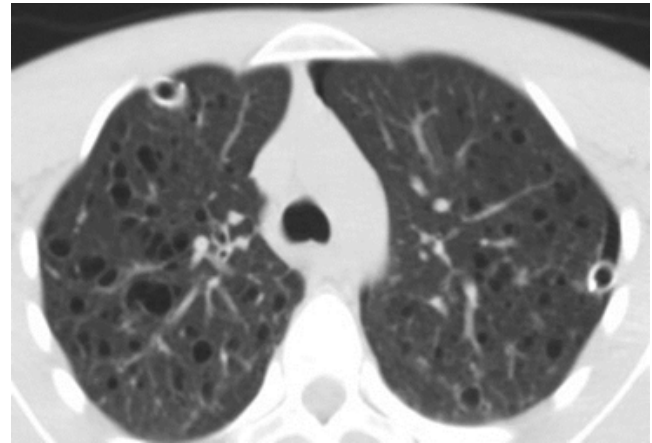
Chest computed tomography scan showing pronounced thin-walled cystic structures smaller than 10 mm in the upper and middle zones
